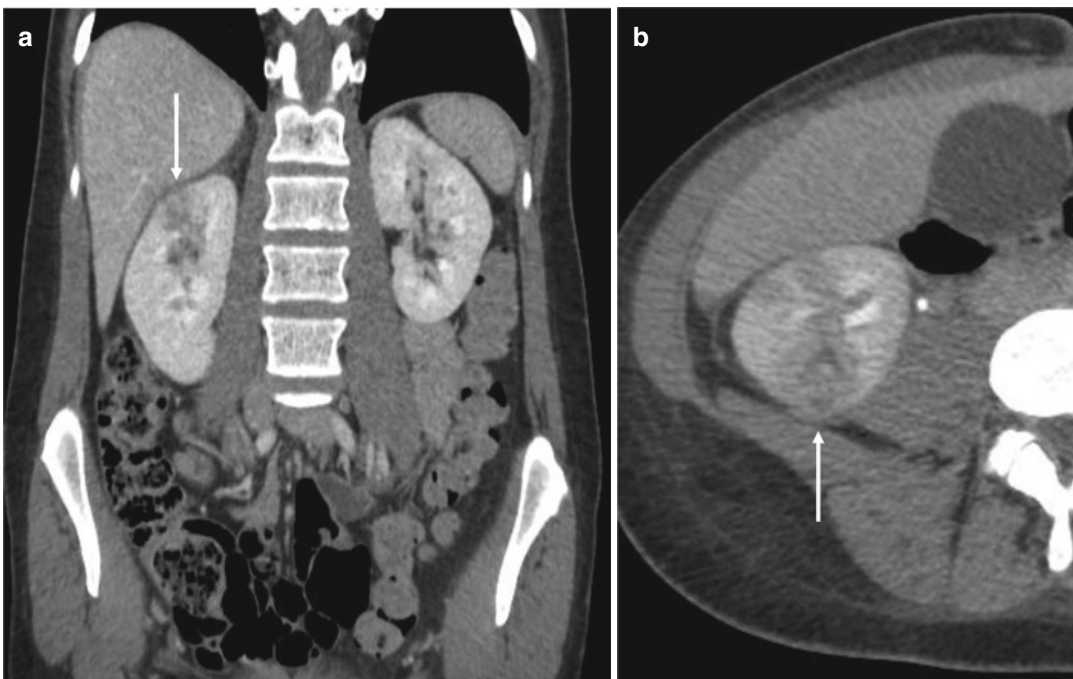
(a, b) CT coronal view (a) and axial view (b) of a 12-year-old patient with acute pyelonephritis: a mass-like area of decreased enhancement is present on the right kidney (arrow)
